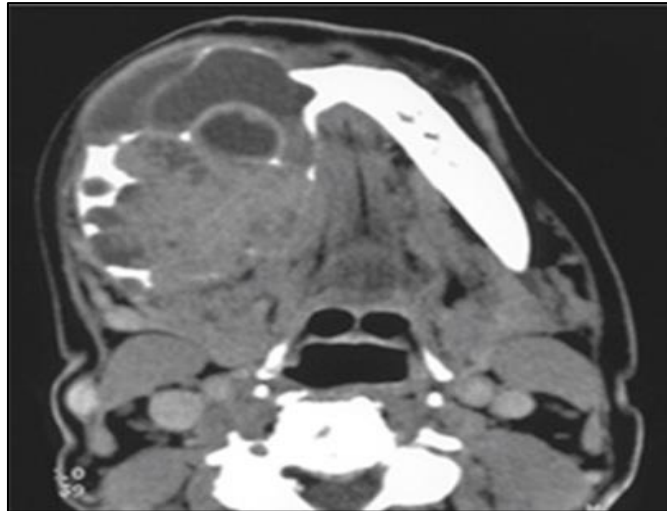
Axial section of the cervico-facial CT showing a large necrotic and ulcerated lesion in the right laterocervical region
